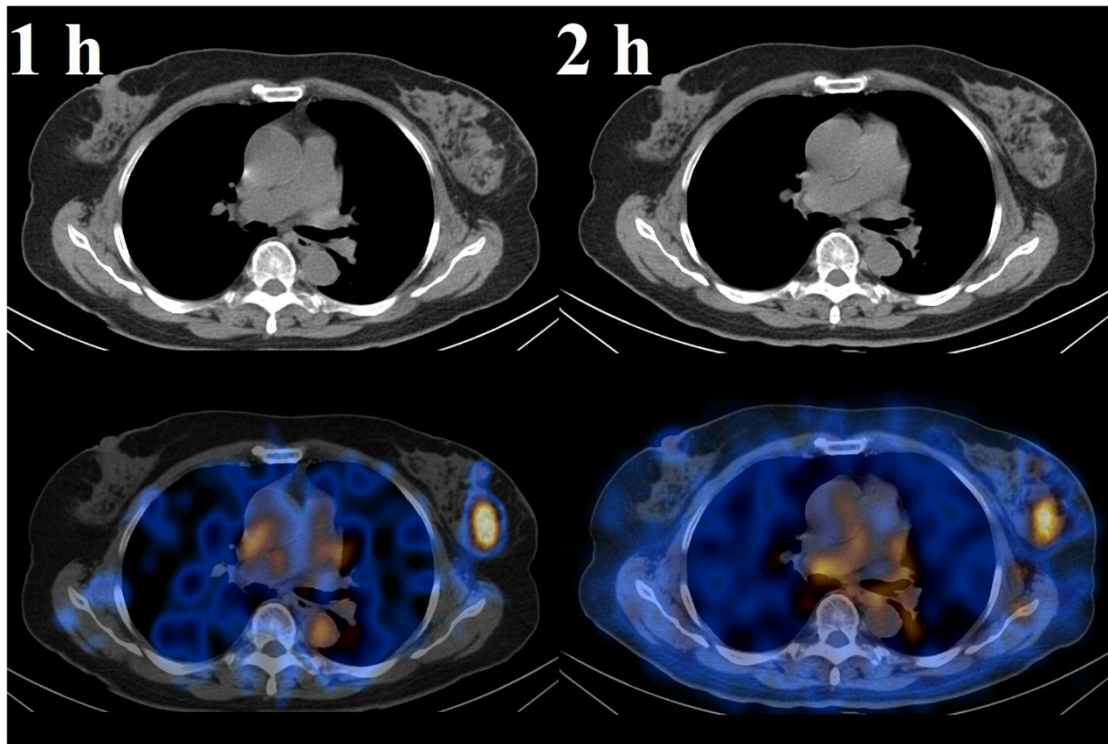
SPECT/CT images of Patient BR005 at 1 and 2 h after injection.
